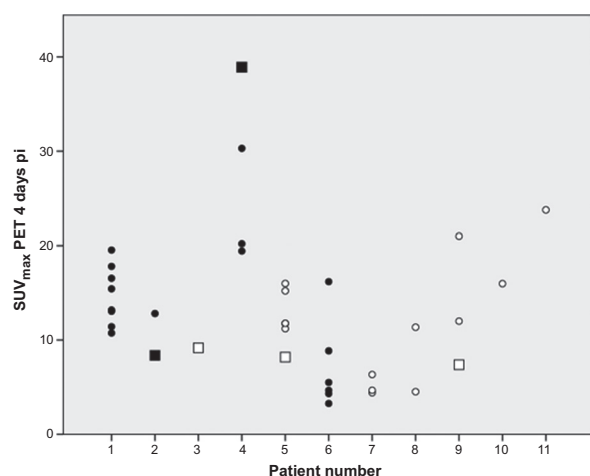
SUV_{max} values at PET 4 days postinjection of all quantifiable tumor lesions ($n = 37$) plotted per patient on the x-axis (7 pancreatic cancer patients with 17 lesions in open dots and 4 ovarian cancer patients with 20 lesions in black filled dots). Squares, primary tumor lesions; circles, metastatic lesions. pi, postinjection.
